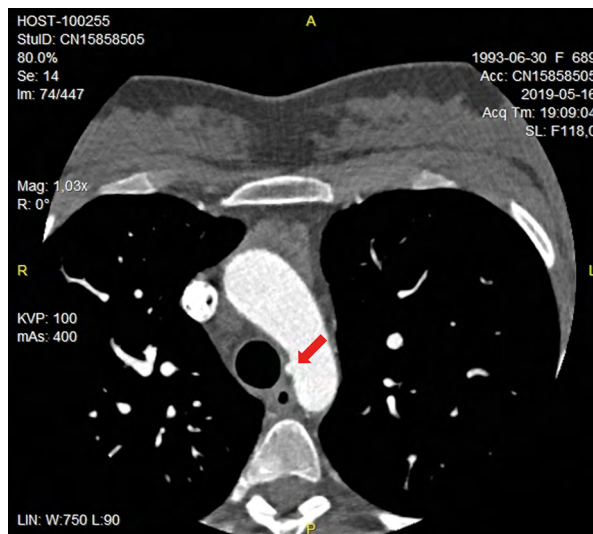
Computed tomography angiography scan – the visible anomalous origin of a single coronary artery in the aortic arch (red arrow)
